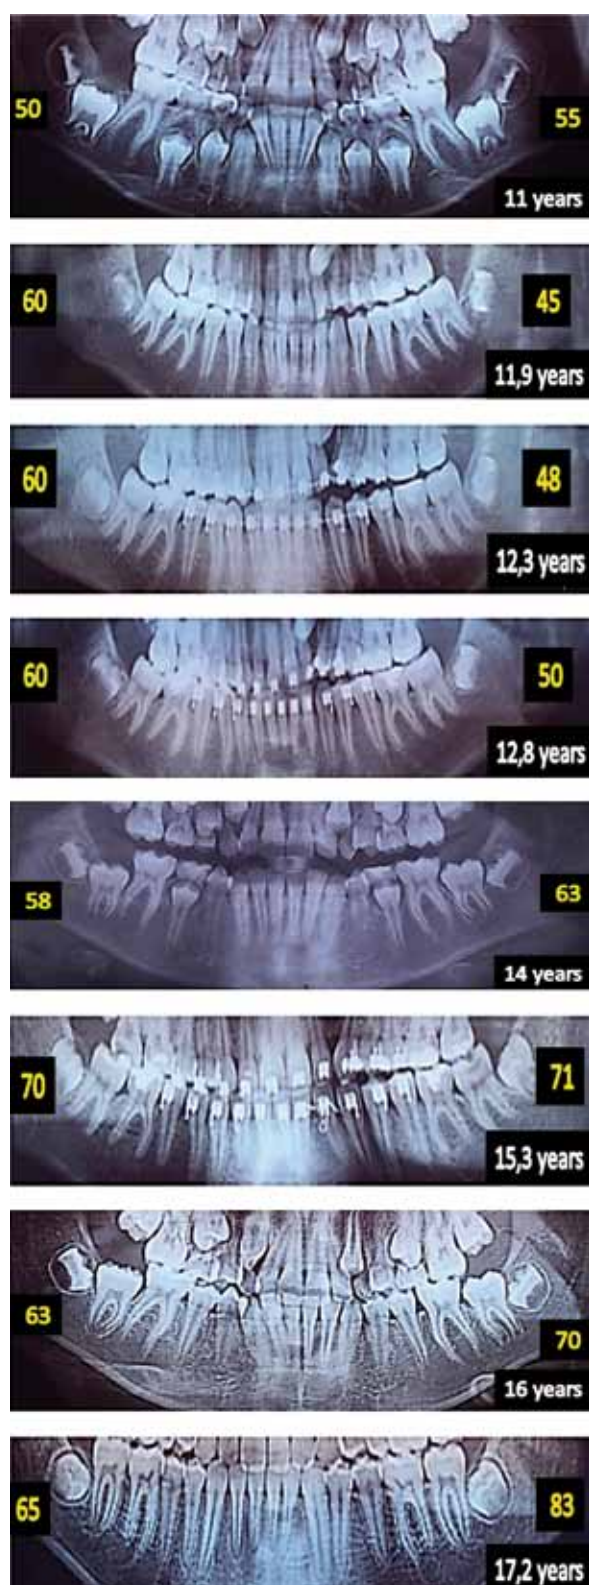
A selection of orthopantomograms of the jaws, with the location of the roots of the third molars with a distance from the buttresses (the angles of the 3 molars are shown in yellow, the age of the patient is indicated in white)
